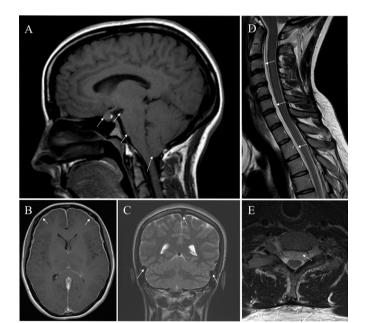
Typical MRI findings of spontaneous intracranial hypotension (SIH). (A) Sagittal T1 image showing enlargement of the pituitary, decreased mamillopontine distance, sagging of the brainstem and cerebellar tonsillar descent. (B) Axial T1 postcontrast image showing diffuse smooth dural thickening and pachymeningeal contrast enhancement. (C) Coronal T2 image showing distension of the dural venous sinuses. (D) Sagittal T2 image showing extensive ventral spinal longitudinal epidural collection (SLEC) extending from the upper cervical to thoracic regions. (E) Axial T2 image showing ventral SLEC.
